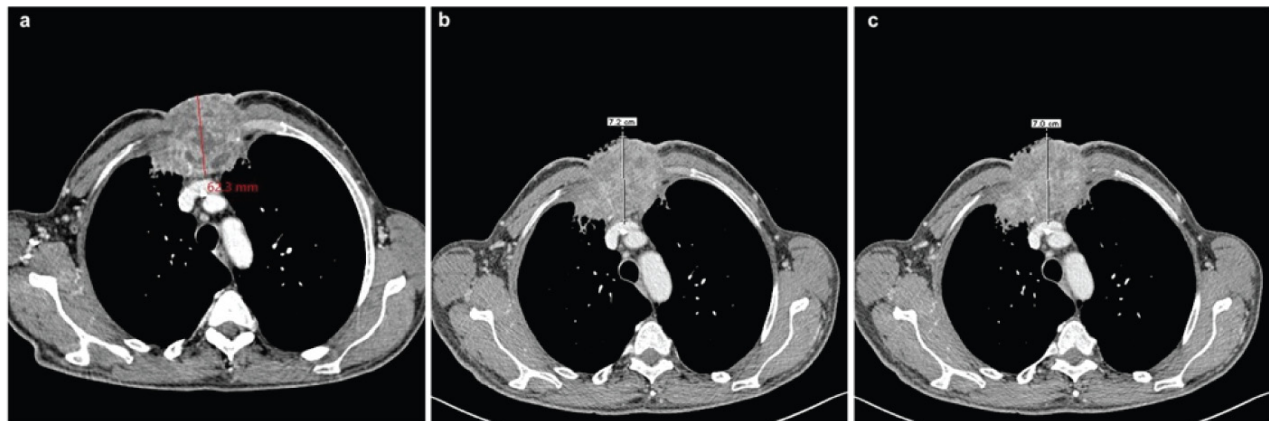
CT scan performed at baseline (a), after six (b) and 12 weeks of therapy (c), highlighting the anterior-posterior diameter of the tumor.
